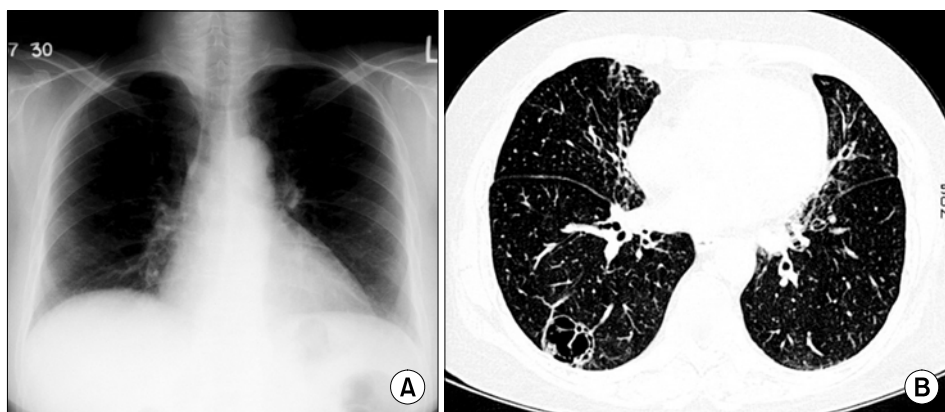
Chest radiography (A) and HRCT scan (B) at initial presentation, demonstrating a well-defined multi-septated cavitary lung lesion in the superior segment of the right lower lobe.
